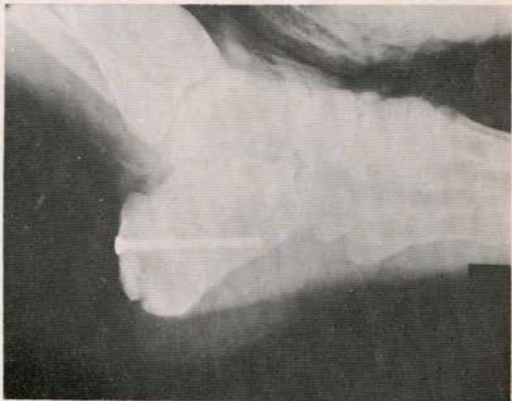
X-Ray appearance after open reduction and screwfixation.
